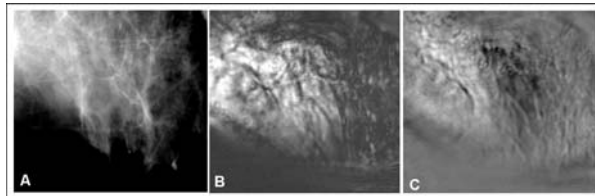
(A) x-ray image of a breast, arrow points an eggshell calcification, (B) VA image of this breast at depth 3.5cm is shown. The eggshell calcification can be seen at the same location of x-ray (block arrow); three arrows point some small microcalcifications in left medial and lower part of the image.
